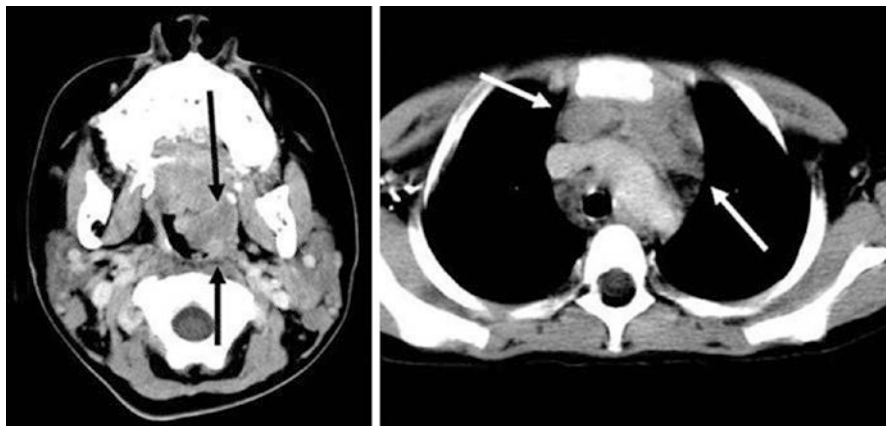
Older child after liver transplantation. CT reveals left tonsillar nodal mass and mediastinal adenopathy. (Courtesy of Dr. David Manson, Hospital for Sick Children, Toronto)
